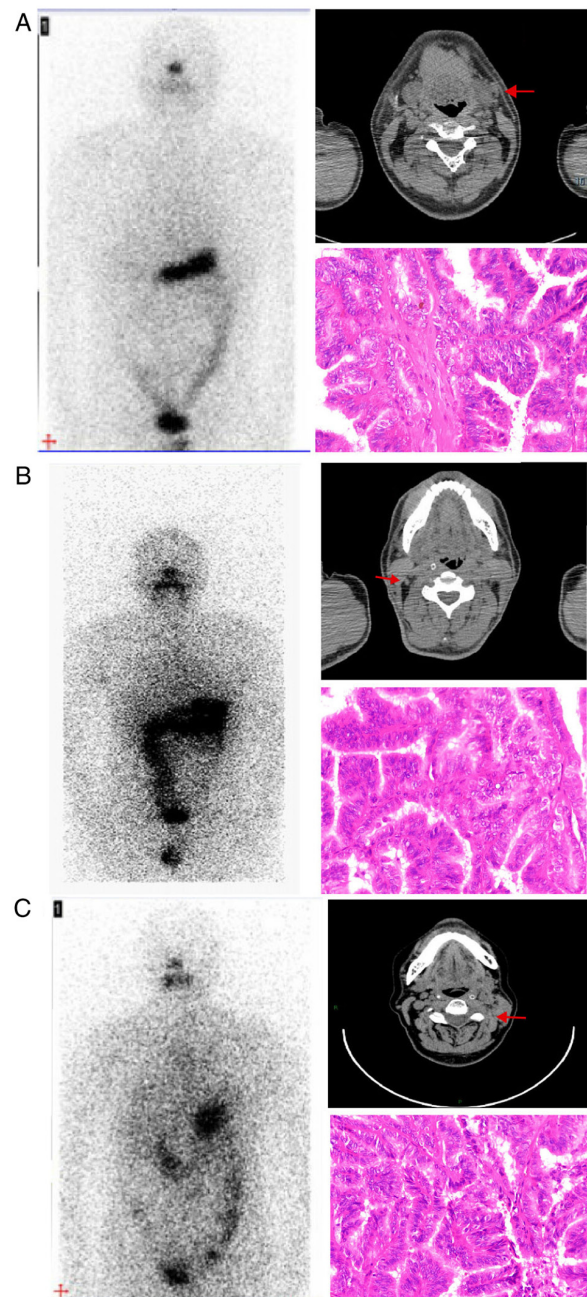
Imaging characteristics and pathological sections of three patients with RR-DTC who were subjected to proteomic analysis. (A) Patient 1, a 31-year-old male. One metastatic lymph node was detected on the left side of the neck (red arrow) by CT imaging (upper right panel) while no abnormal radioactive 131-iodine uptake was observed by WBS (left panel). (B) Patient 2, a 49-year-old male. One metastatic lymph node was found on the right side of the neck (red arrow) by CT imaging (upper right panel) while no abnormal radioactive 131-iodine uptake was observed by WBS (left panel). (C) Patient 3, a 52-year-old female. One metastatic lymph node was found on the left side of the neck (red arrow) by CT imaging (upper right panel) while no abnormal radioactive 131-iodine uptake was observed by WBS (left panel). All the lymph nodes obtained from the three patients were verified to be papillary thyroid cancer by pathological sections (x400 magnification; lower right panels). CT, computed tomography; WBS, whole-body scan.
